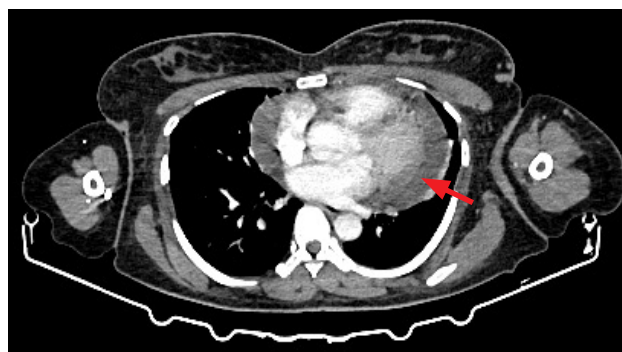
Axial CT scan shows pericardial effusion (red arrow).
